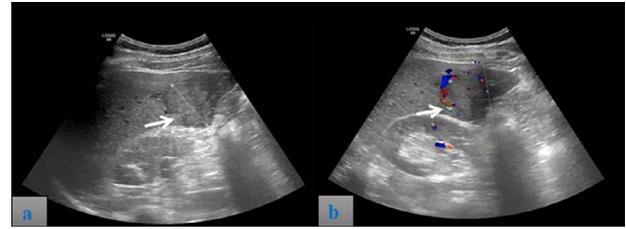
Hepatic lesion in segment VI on ultrasound. (A) Heteroechoic hepatic lesion with irregular contour (arrow) (B). The lesion periphery was hypervascular on Doppler ultrasound (arrow).
